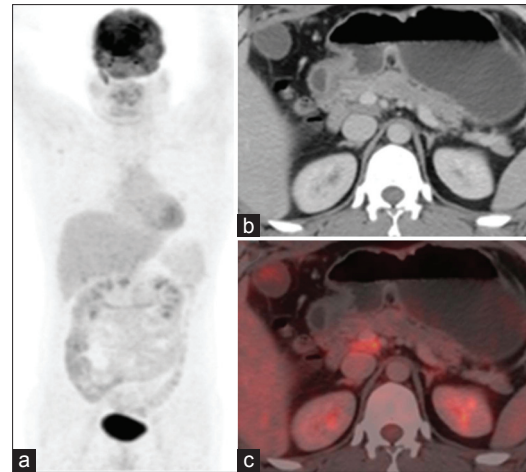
Maximum intensity projection (a), axial computed tomography (CT) (b) and axial fused positron emission tomography/CT (c) images 3 months after starting anti-tubercular treatment, showing complete resolution of the lesions in the pancreatic head and elsewhere. The peripancreatic lymph nodes (b and c) show a significant reduction in size and F-18 fluoro-2-deoxy-D-glucose avidity (standardized uptake value 4.7)
